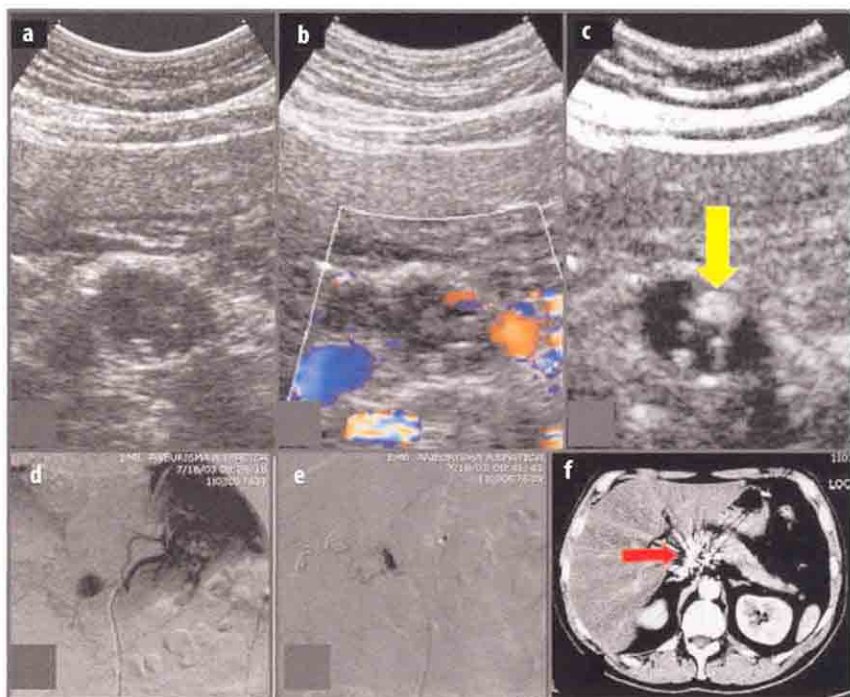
Recanalisation of an hepatic artery aneurysm after metallic coil embolisation. a, b Transversal US and CD scan. In B-mode an oval, 2 cm large image, inhomogeneous in echo-texture and with some internal small hyperechoic spots due to metallic coils, is detectable. The corresponding CD scan demonstrates some colour pixels inside the aneurysm (possibly due to artefacts or persisting flow?). c CEUS scan. After contrast administration, a small hyperechoic nidus (yellow arrow) is detectable inside the aneurysm corresponding to an area of revascularisation. d-f DSA and angio-CT. In F, coarse artefacts (red arrow) due to metallic coils prevent the correct evaluation of the aneurysm with this technique. DSA: diagnosis (d) and post-embolisation control (e)
